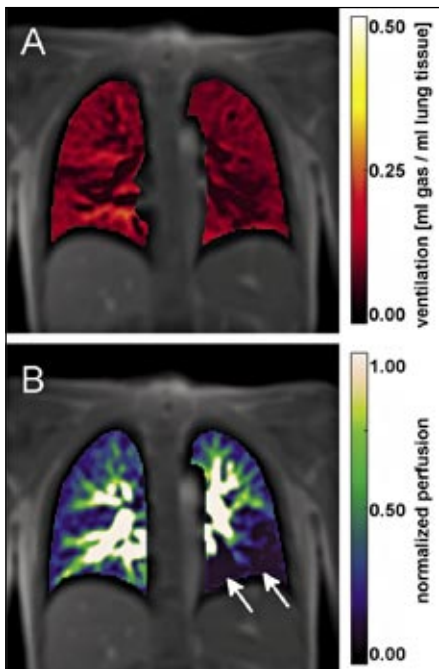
Ventilation-weighted maps (A) acquired by SENCEFUL-MRI show the ventilation in ml air per ml lung tissue. This example shows a homogeneous ventilation in a 30 year old patient. The corresponding semiquantitative perfusion-weighted map (B) shows a reduced perfusion of the left lower lung caused by regional pulmonary embolism, which was previously diagnosed by lung scintigraphy.
